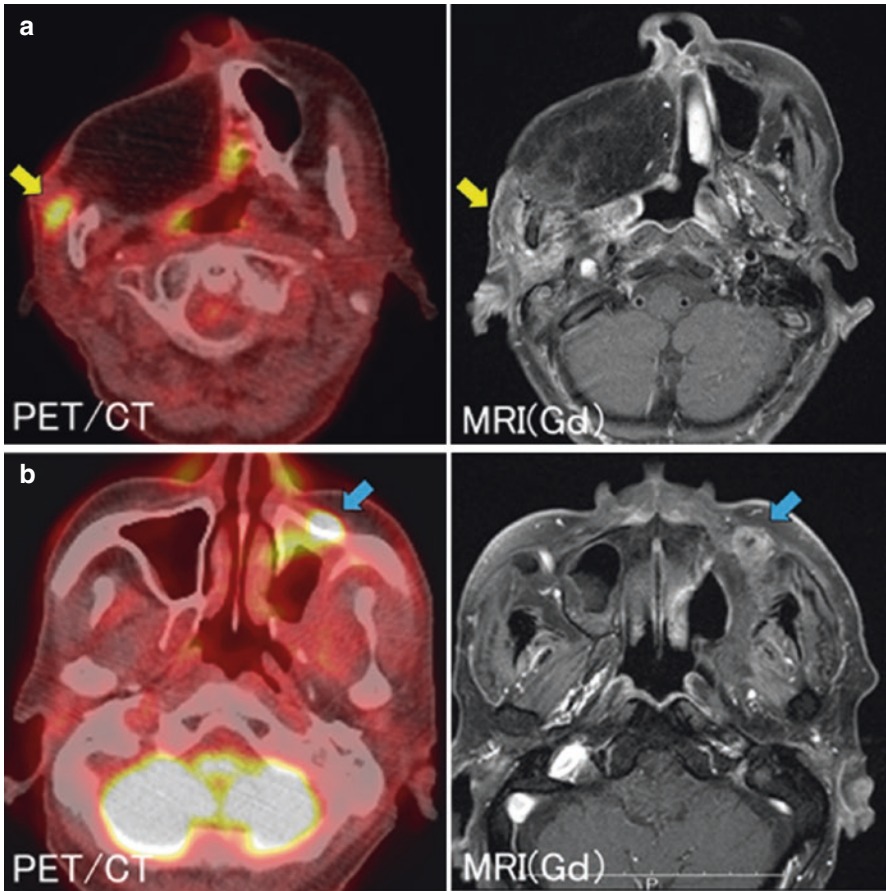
Detection of recurrence of head and neck cancer using FDG PET/CT. (a) An 84-year-old woman with a right maxillary sinus squamous cell carcinoma (SCC). The patient underwent right total maxillectomy with reconstruction using a free rectus abdominis myocutaneous flap. Follow-up PET/CT at 8 months (left) shows local recurrence (yellow arrow). Contrast-enhanced MRI shows equivocal findings (right). (b) An 81-year-old man with a left superior gingival SCC. The patient underwent left partial maxillectomy without reconstruction. Follow-up PET/CT at 9 months (left) reveals perineural spread of a recurrent tumor along the left inferior orbital nerve (blue arrow). Contrast-enhanced MRI (right) also clearly identifies the perineural spread. (c) A 49-year-old woman with a right parotid gland adenocarcinoma not otherwise specified. The patient underwent right total parotidectomy. Follow-up PET/CT at 4 months reveals perineural spread of a recurrent tumor along the right mandibular nerve (V3) beneath the foramen ovale (red arrow). The tumor is located near the brain, where there is high physiological FDG uptake; however, coronal PET/CT images can clearly identify the lesion
